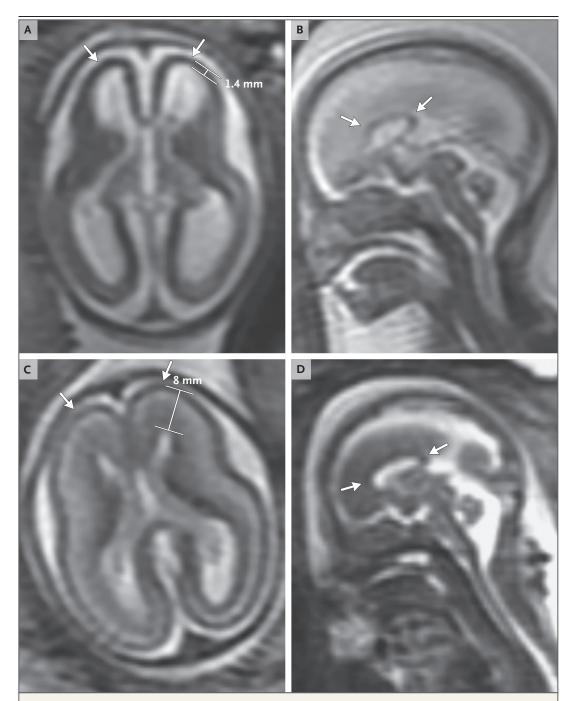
Magnetic Resonance Imaging of the Fetal Brain at 19 Weeks of Gestation.
